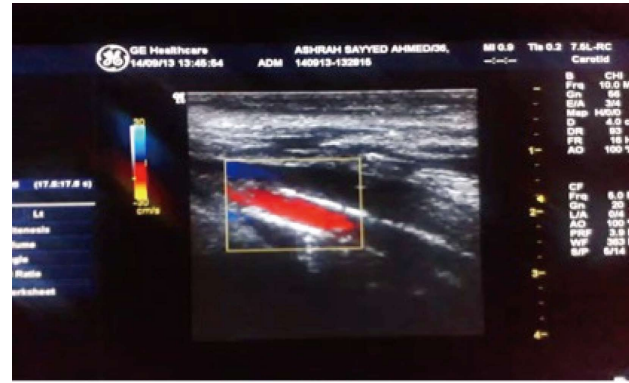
Doppler study of popliteal artery, the vessel wall shows linear calcification.
